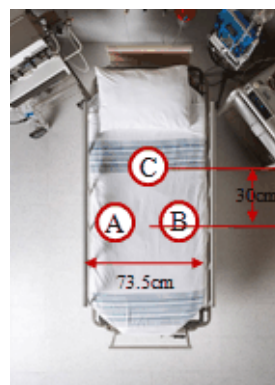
Experiment Task Design. Participants assumed the role of a sonographer and conducted pseudo scanning tasks on three distinct locations.
